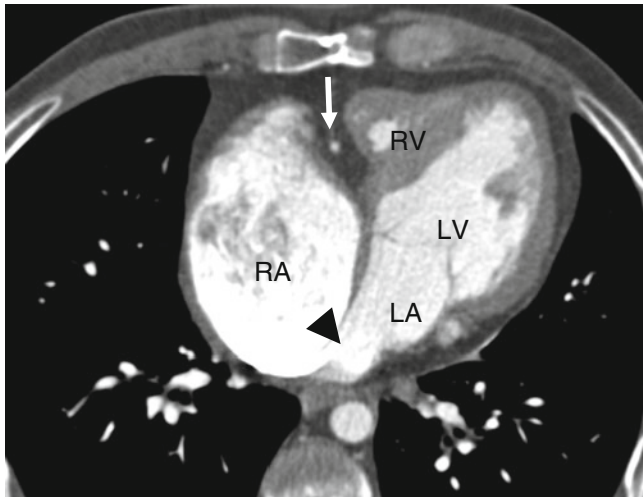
Tricuspid atresia. An axial computed tomogram showing fat in the atrioventricular groove (*arrow*). The right atrium (*RA*) is enlarged and the right ventricle (*RV*) is hypoplastic. The *black arrowhead* points out the obligatory atrial septal defect. *LV* left ventricle, *LA* left atrium
